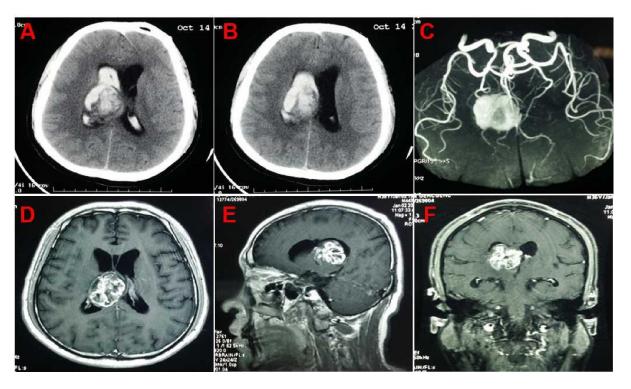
CT scan showing intraventricular hemorrhage and hydrocephalus simutaneously (A,B). MRA demonstrating show space-occupying lesion in the right trigone of lateral ventricles (C). Axial (D),sagittal (E) and coronal (F) gadolinium-enhanced T1-weighted MRI showing the inhomogeneously enhancing lesion in the right trigone of lateral ventricles.
